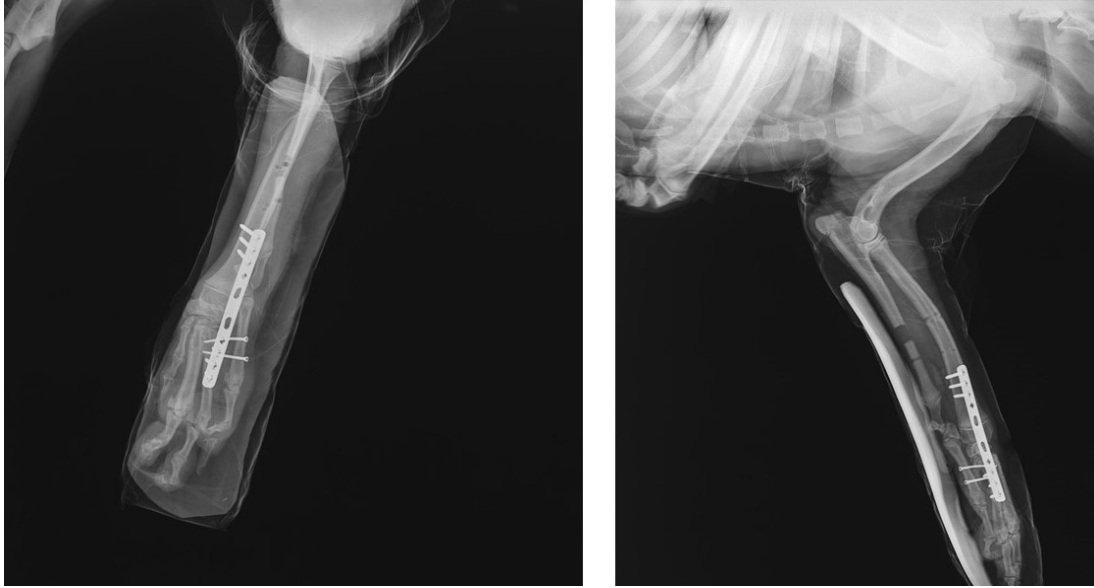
A / P and M / L view of the extremity on postoperative radiographic images.
